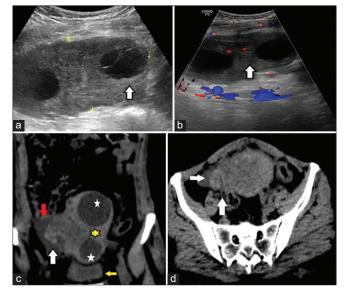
(a and b) Transabdominal ultrasonography (USG) images. (a) Gray scale USG showing enlarged right ovary in midline just below the anterior abdominal wall with two internal cysts. Internal septations suggesting internal hemorrhage were seen in a cyst (arrow), (b) Color Doppler USG showing decreased internal vascularity, (c) Noncontrast computed tomography (NECT) image. NECT coronal (c) and axial (d) images of abdomen-pelvis reveals – enlarged right ovary of 11 cm × 6.0 cm size (yellow asterisk) placed in midline superior to partially distended urinary bladder (yellow arrow). The ovary shows two variable-sized cysts (white asterisks). Note the engorged hyperdense vessels in twisted pedicle – giving whirlpool sign appreciation even on noncontrast images (white arrows). Free fluid also seen (red arrow)
